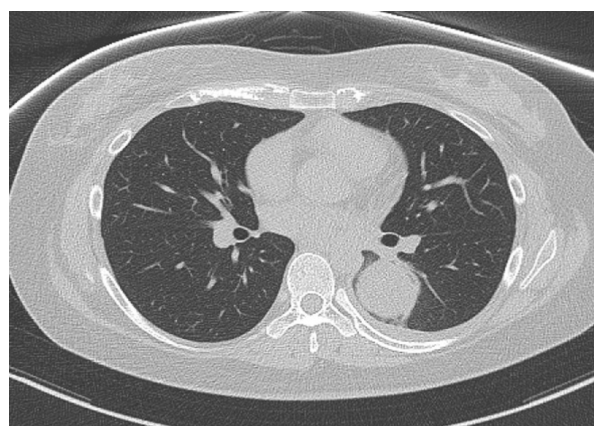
On axial computed tomography, 5.3 cm-sized mass was in contact with the posterior mediastinum and accompanied by left pleural effusion.
